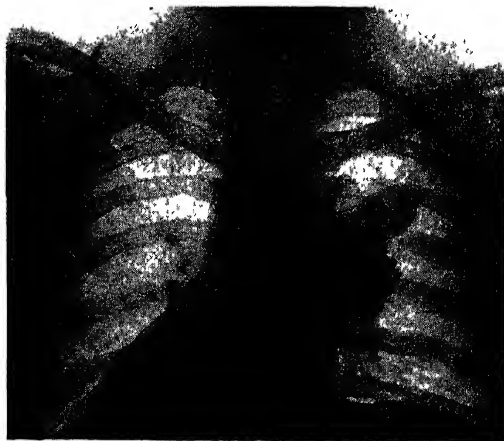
C—Roentgenogram of chest ten months after thigh amputation shows metastatic tumor mass near the hilum of right lung. (Hatcher, C. H.: *J. Bone & Joint Surg.* 27: 179 (April) 1945.)
